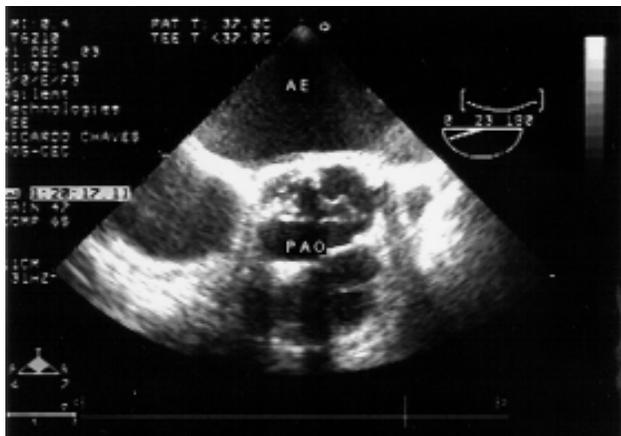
Intraoperative transesophageal Doppler echocardiogram of case 2 - The 'Less Stented' prosthesis with normal opening and functioning
